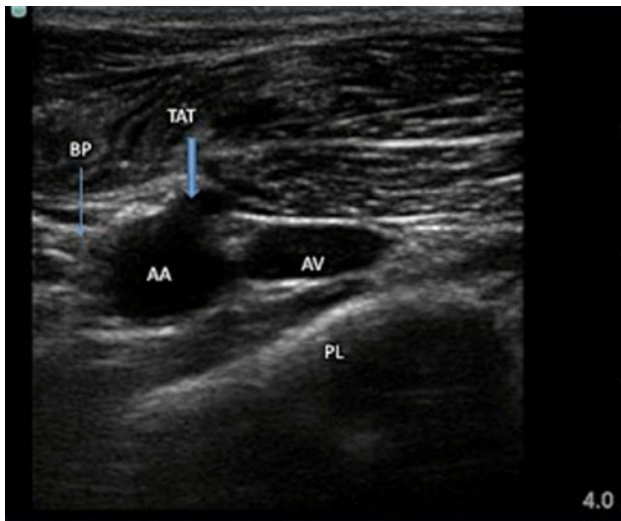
Cross-sectional image of the infraclavicular axillary vessels as viewed from the *right* side of the patient. The depth of field is 4.0 cm. The axillary vein (AV) lies close to the axillary artery (AA) with the chest wall and pleura (PL) below. A significant branch of the axillary artery the thoraco-acromial trunk (TAT) is shown, which branches out with tortuous anterior branches crossing over the vein. The brachial plexus (BP) is typically in close proximity to the artery. High-resolution ultrasound and accurate needle visualisation allow such collateral structures to be identified and avoided
